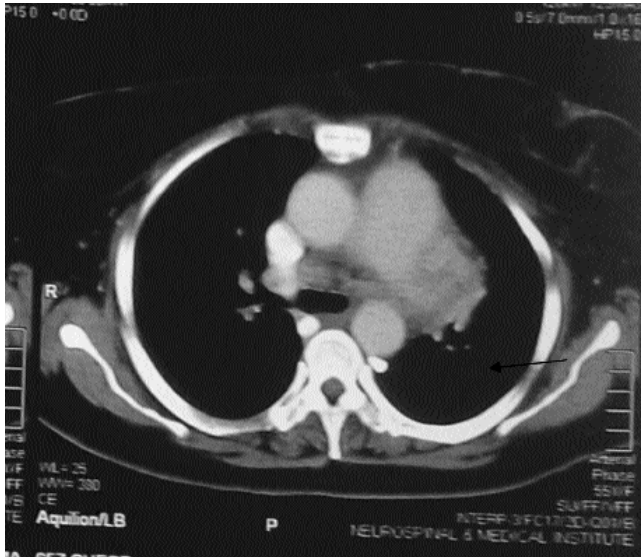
CT-scan chest (mediastinal window) shows a soft tissue density mass (arrow) present along the pulmonary artery and aorta.
